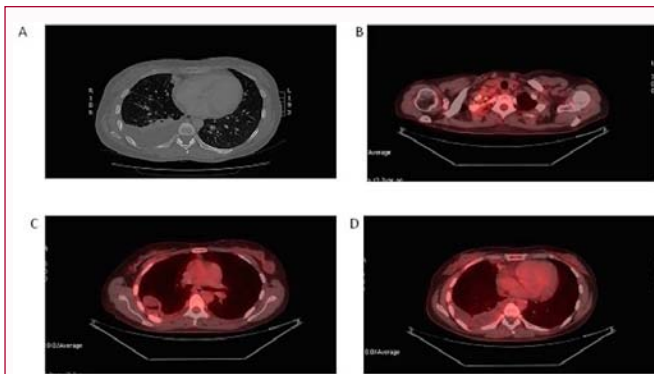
CT scan revealed right pleural effusion with paramediastinic mass (A) and PET/CT showed slight increased uptake in the paramediastinic lesion and in the right parietal pleura (B-D), in particular in the apical portion (B).
